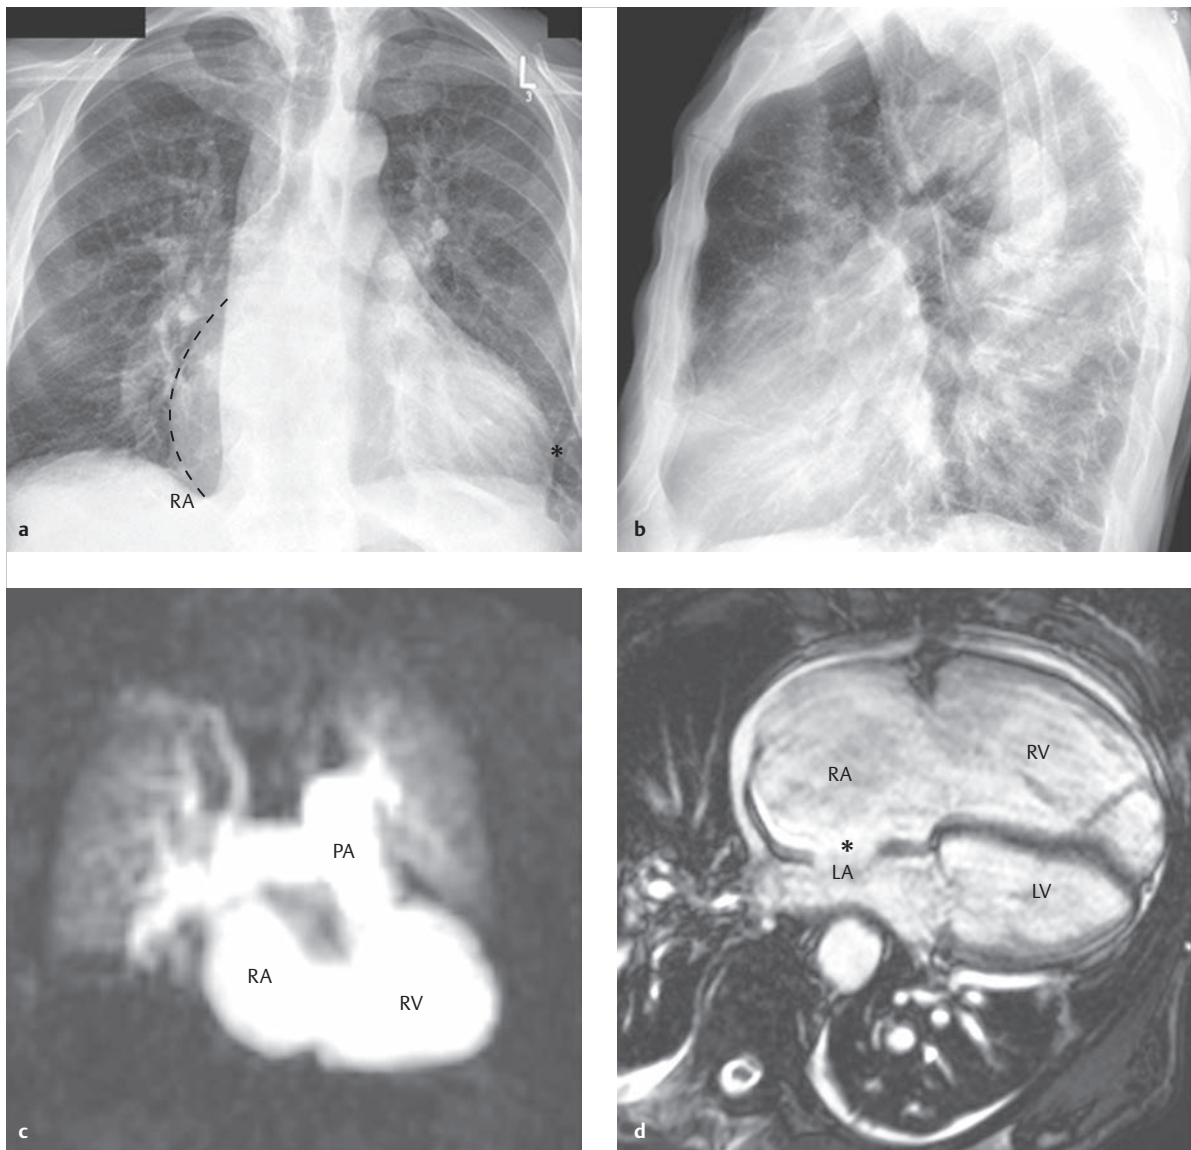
Superior SVD and partial anomalous connection of the right pulmonary vein to the superior vena cava. Seventy-nine-year-old male patient (the same patient as in ► Fig. 4.133 and ► Fig. 4.134). The thoracic X-rays (a, b) depict a significantly enlarged, margin-forming right atrium and ventricle that displaces dorsally the left ventricle, forming the left margin, in addition to other X-ray morphological indicators of pulmonary hypertension (see MRI d). The dynamic, contrast-enhanced MRA (c) clearly depicts the dilated pulmonary arteries in the presence of known pulmonary hypertension, during the pulmonary arterial phase. The pulmonary perfusion is equal bilaterally. Both SSFP cine MRI (d) and 2-D TTE images (e–g) depict the massively enlarged right ventricle, with an internal diameter of 63 mm. MRI volumetric analysis resulted in a right ventricular EDV of 226 ml/m² and a reduced right ventricular ejection fraction of 38%.
